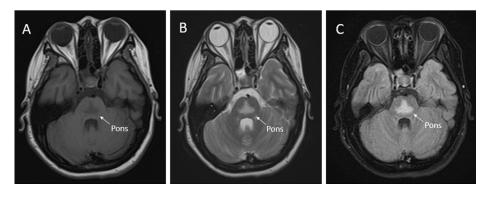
The magnetic resonance imaging (MRI) of the brain (A: T1-weighted showed hyposignal intensity, B: T2-weighted showed hypersignal intensity, C: fluidattenuated inversion recovery (FLAIR) image showed hypersignal intensity) at the mid-pons.
